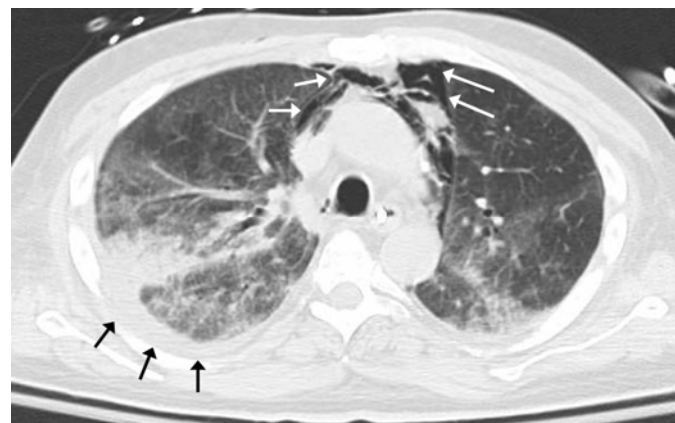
Contrast-enhanced axial CT image through mid-lung fields shows persistent pneumomediastinum (short white arrows), persistent left side-pneumothorax (long white arrows), right side pleural effusion (black arrows), and ground-glass attenuation with focal consolidations in bilateral lung bases.
